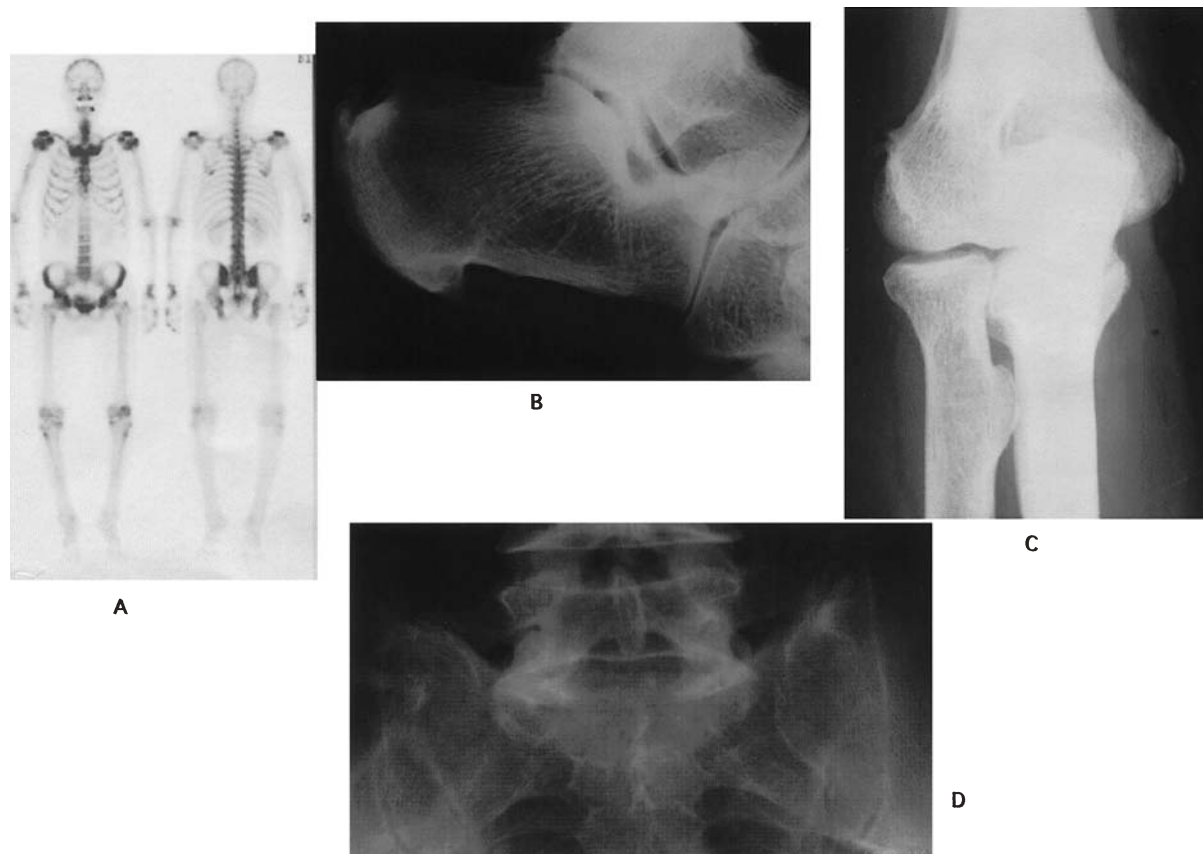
Bone image showing sacroiliac arthritis and enthesopathy. A Bone scintigraphy. B X-ray of left Achilles tendon attachment site. C X-ray of right elbow. D X-ray of lower spine and sacroiliac joint
